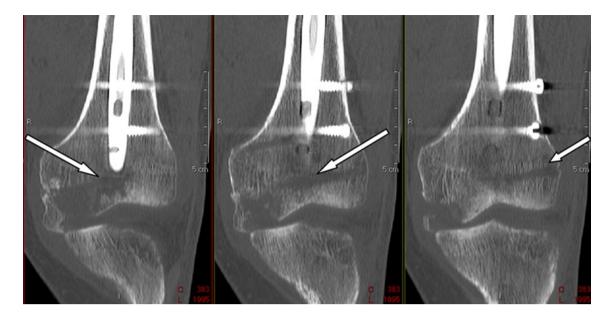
Parietal reconstruction of the post-operative CT scan of the left knee: the *arrows* show the position of the formerly used traction pin; there seem to has been a conflict with the advancing IM nail, possibly causing the medial condyle fracture
